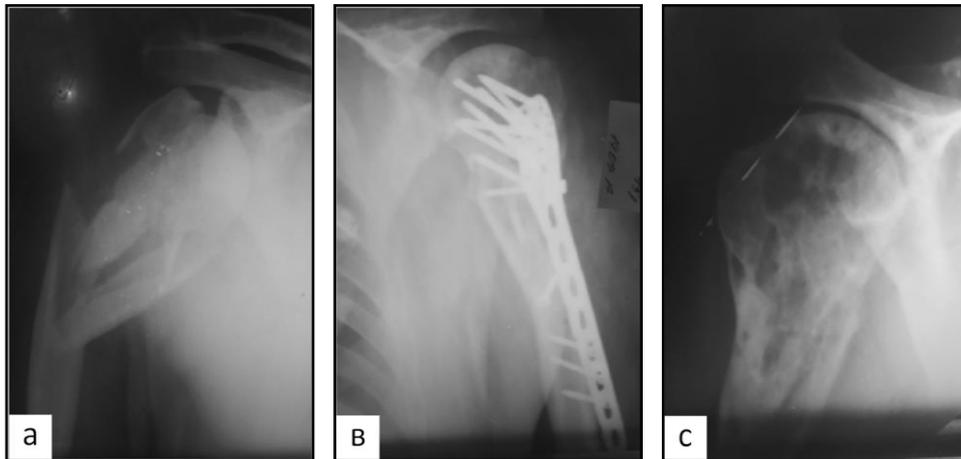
X-ray of patient D., 45 years, before and after osteosynthesis with screws: before surgery (a), after surgery (b), 4 months later after metal constructions (c).
